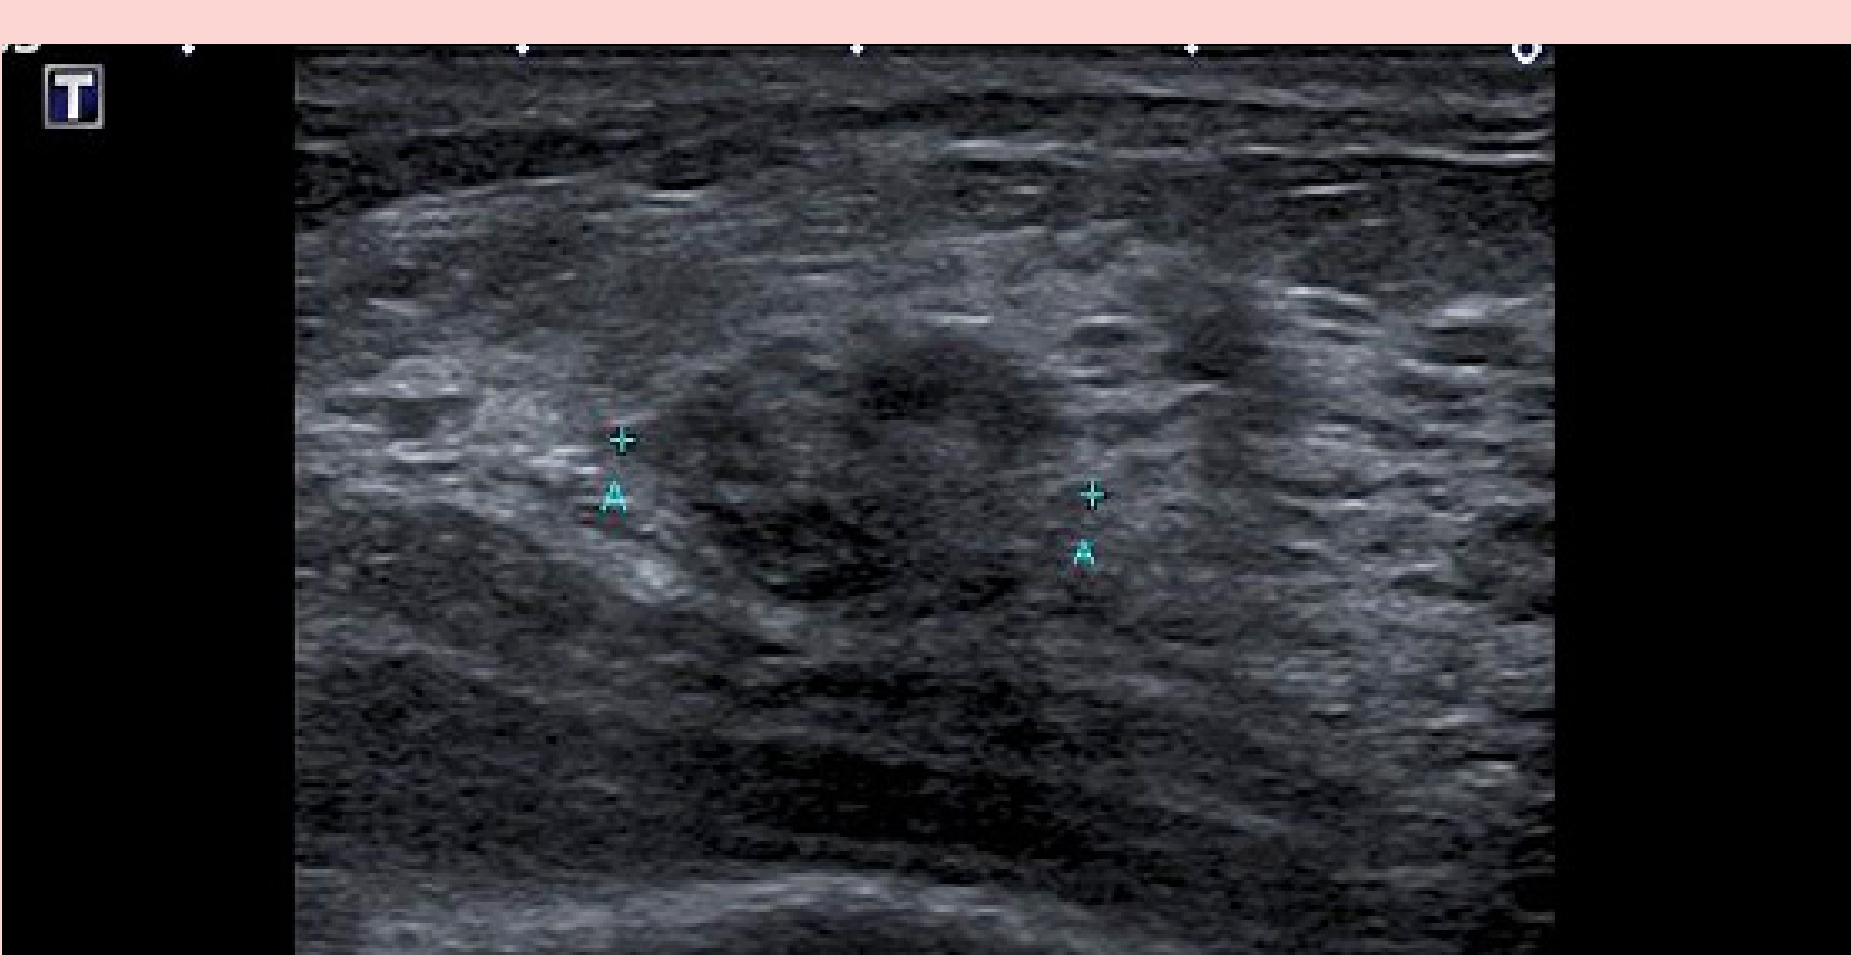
Ultrasound examination on re-presentation 8 months later. This was classified as U3.
